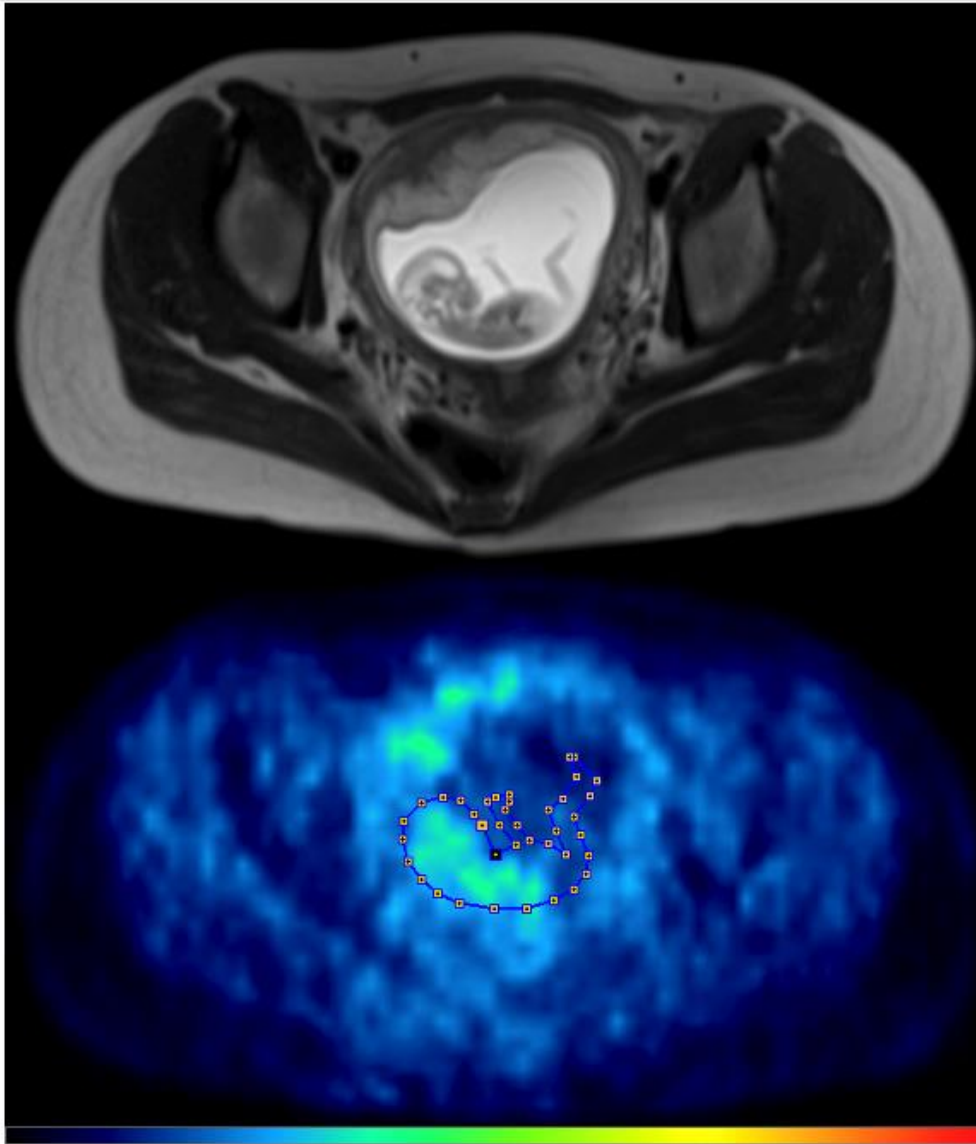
Transaxial images of MRI and PET in a woman at 13 weeks of pregnancy. The fetus is visible in minute detail on the MRI, including body parts, such as limbs, that are “cold” on the PET images. The figure demonstrates how the region of interest drawn around the fetal body, shown superimposed to the PET scan below, would not have been drawn with this shape if only PET images had been available. It is thus reasonable to hypothesize that fetal dosimetry obtained with PET/MRI is more accurate than that obtained with PET-only or PET/CT scans.
